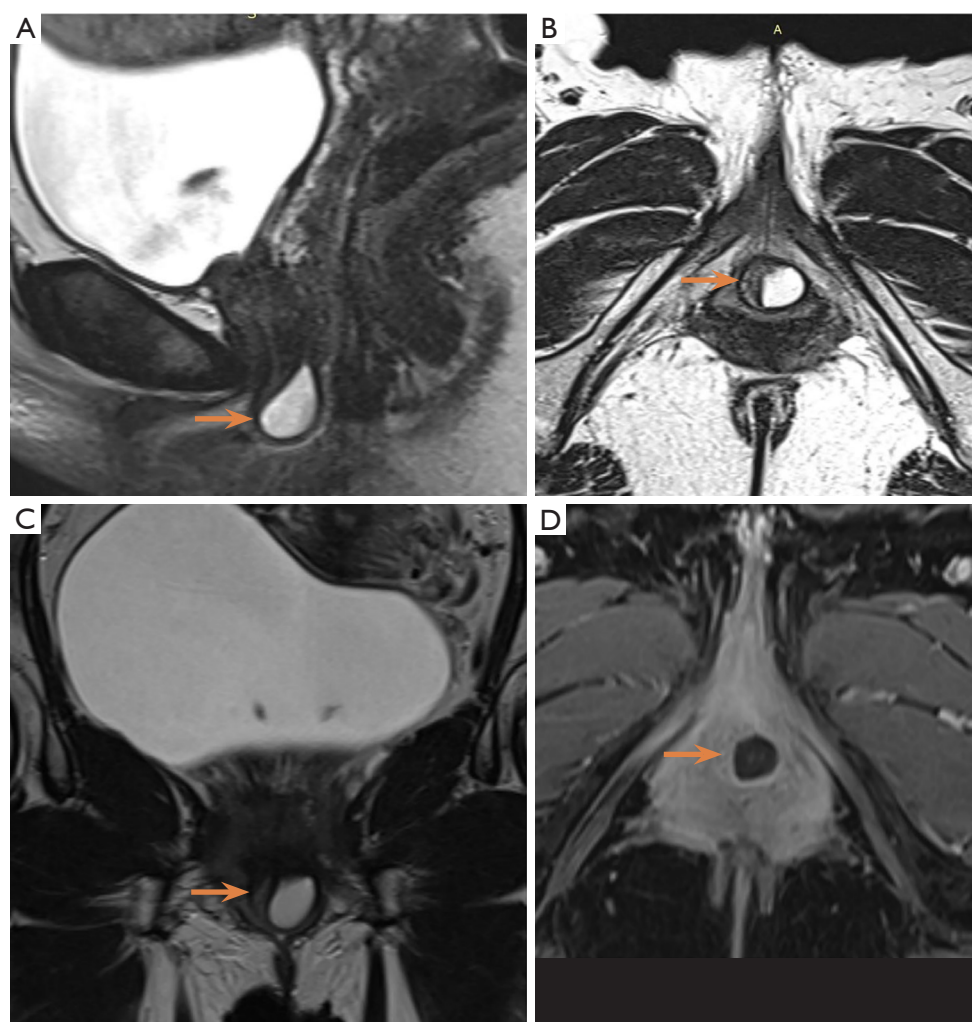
Pelvic MRI with VSD showing a left-sided, posterolateral, teardrop-shaped Skene's gland cyst (orange arrows) in the distal third of the urethra. The lesion appears hyperintense on T2-weighted images (A-C) and shows minimal peripheral enhancement on T1 fat-saturated post-contrast imaging (D). No signs of complication are present. MRI, magnetic resonance imaging; VSD, vaginal saline distension.
